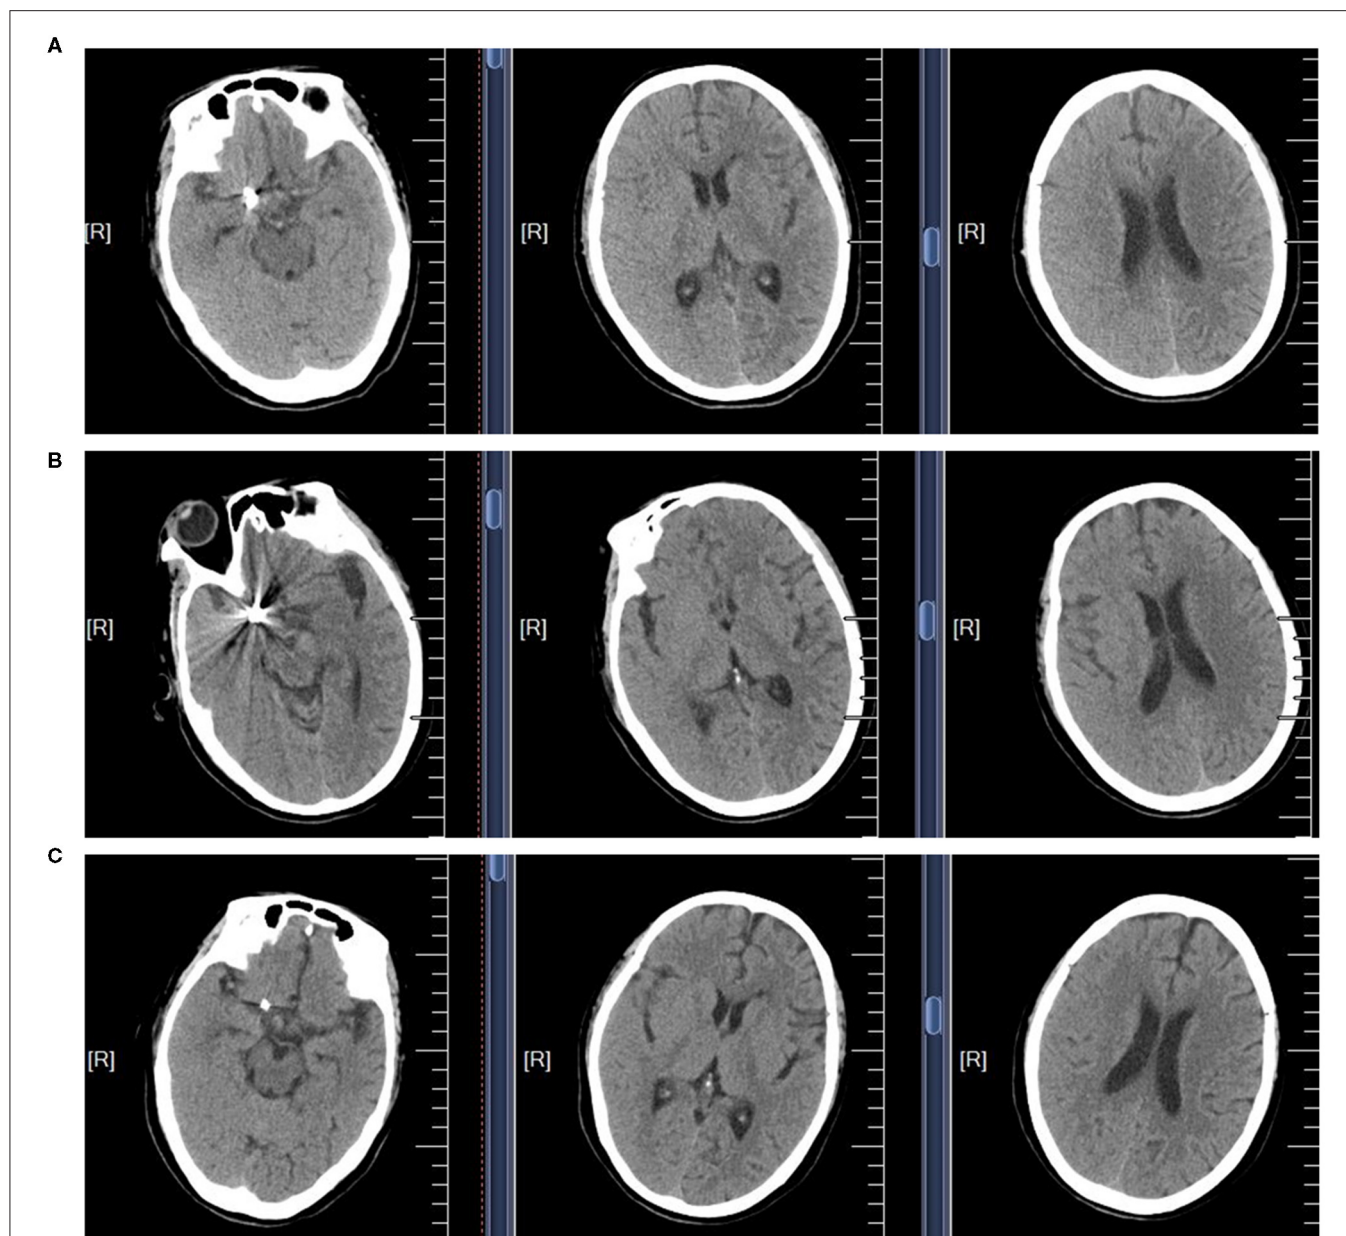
The non-contrast CT scans of the brain in CIE patient. (A) The brain CT scan performed immediately after the operation. (B) The brain CT scan performed in the following day. (C) The brain CT scan performed in the third day.
